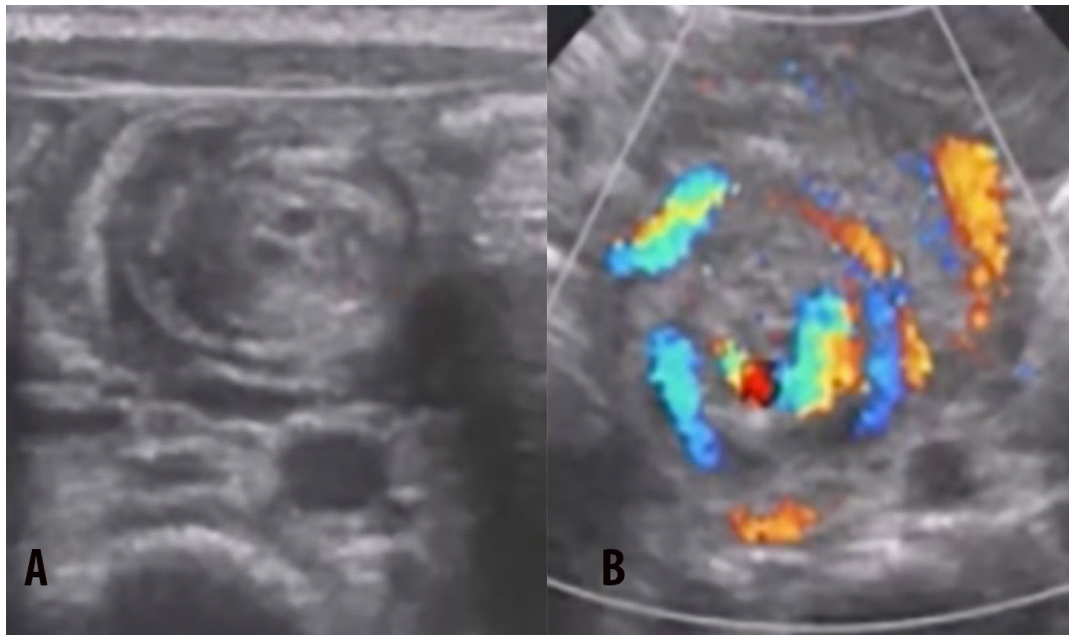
(A) Ultrasound in grey scale showing of 'whirlpool' sign and (B) in colour doppler
